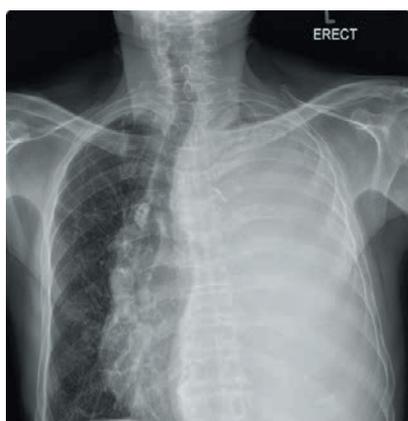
A chest radiograph showing a massive left-sided effusion with midline shift to the right.
